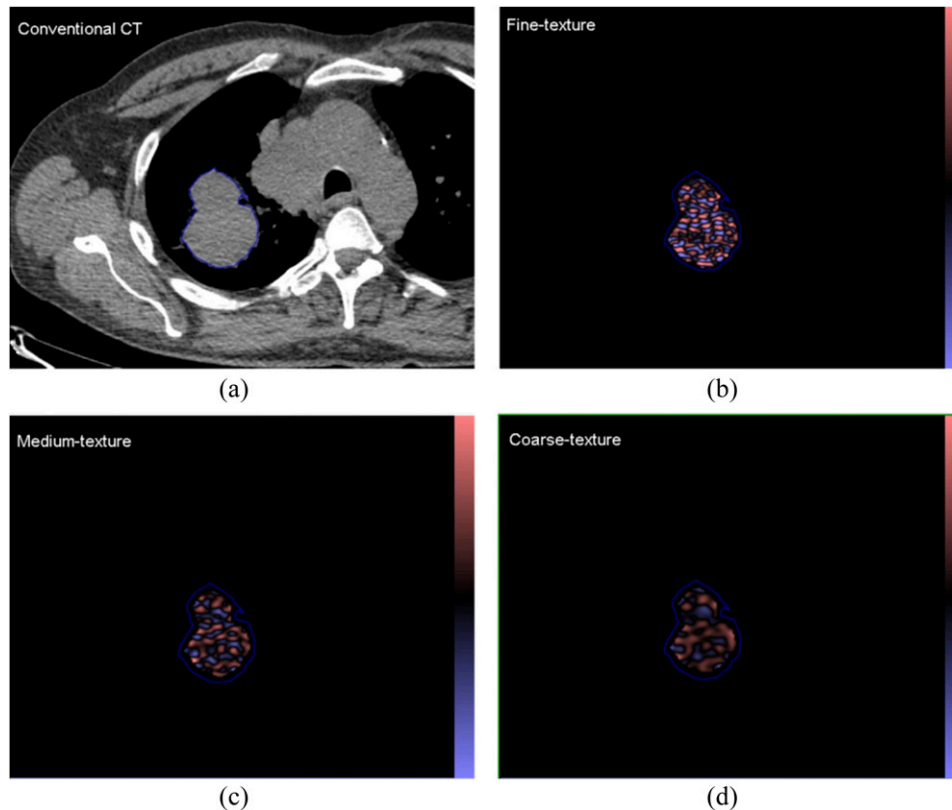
(a) A conventional CT (from a positron emission tomography/CT) image of a patient with a lung lesion and (b–d) corresponding images selectively displaying fine, medium and coarse texture obtained from TexRAD CT texture analysis (image heterogeneity) commercial research software (www.texrad.com, Radstock, UK). Images should be viewed in the online format.
